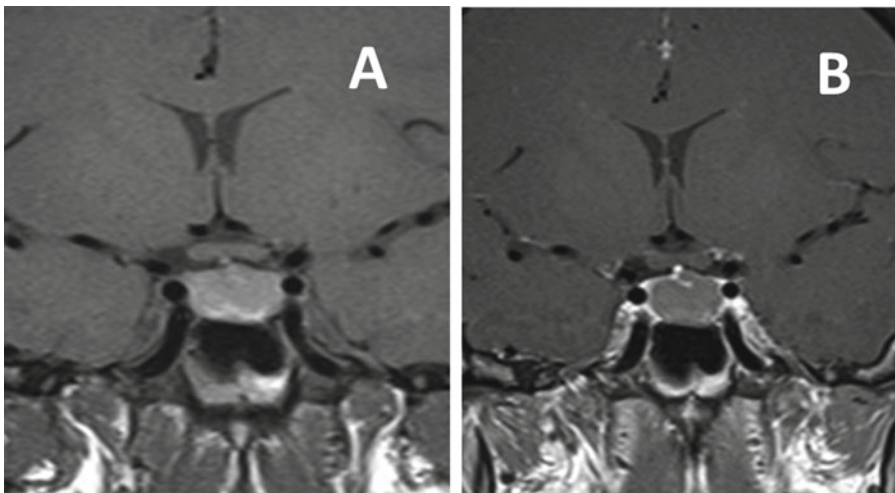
MRI T-1 weighted images in the coronal plane showing an intrasellar Rathke's cleft cyst. Prior to contrast (a) the cyst shows mild increased intensity compared to normal brain. After gadolinium (b) the cyst does not enhance
